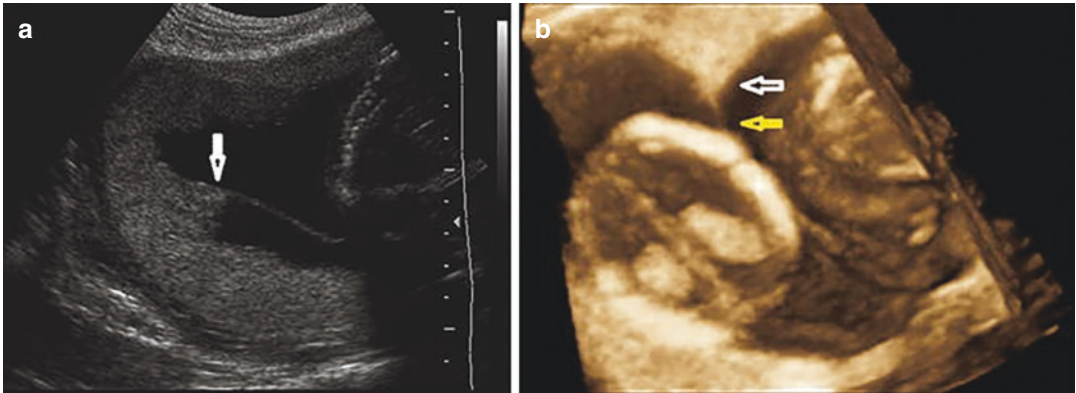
Twin-peak or lambda sign. Two-dimensional B-mode (a) and three-dimensional (b) ultrasound of a dichorionic diamniotic pregnancy. The white arrows point to where the “peak” is formed from the two placentas
